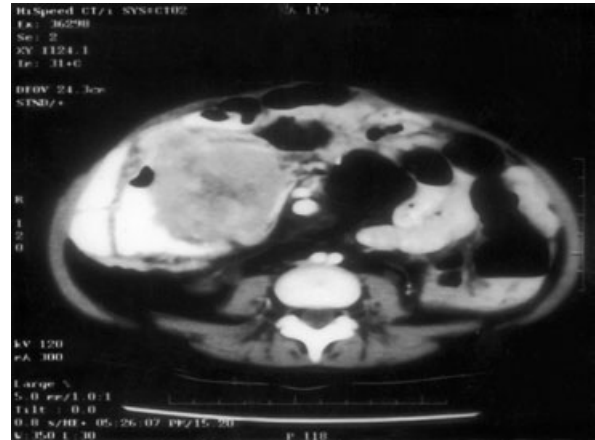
Abdominal CT-scan showing the intestinal allograft tumor.
